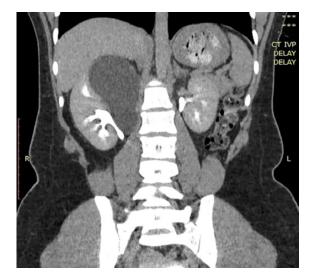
Coronal CT IVP image at the level of the kidneys pre-intervention demonstrating hydronephrosis of the upper moiety of the right kidney with no excretion noted. The lower moiety of the kidney demonstrates a normal collecting system with the typical "drooping lily" sign and excretion of contrast into a normal uneter.
